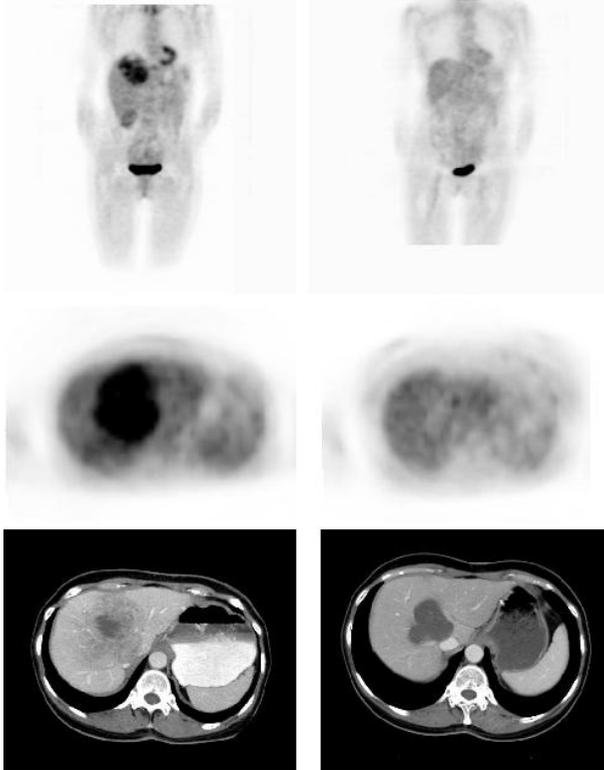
Left: FDG-PET scan (upper and middle figures) and CT scan (lower figure) of a patient with GIST with tumor metastases in the liver before start of imatinib therapy. This patient had a partial resection of the stomach due to a GIST. However, one year after the resection, large metastases were observed in the liver. Both the left and the right lobes of the liver show intense FDG uptake. Right: FDG-PET (upper and middle figures) and CT (lower figure) evaluation after 2 months of imatinib therapy. No pathological FDG uptake can be observed in the liver. Physiological FDG uptake can be seen in the heart, kidneys, bladder and the gut. By contrast residual tumor on CT remains considerable. Conclusion: An adequate metabolic response following imatinib treatment. Abbreviations: FDG-PET, fluorodeoxyglucose-positron emission tomography; CT, computed tomography; GIST, gastrointestinal stromal tumor.
